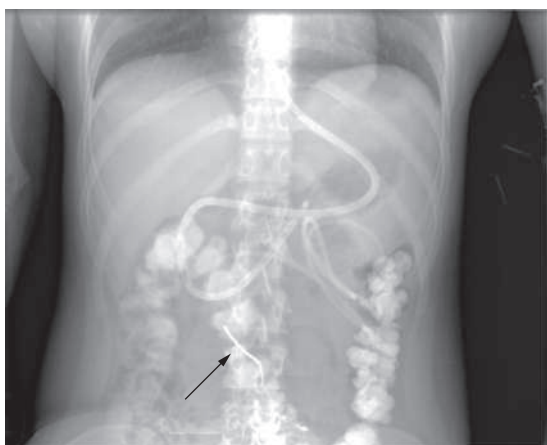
Radiographic image of the patient in Figure 3 that shows the final placement of a double-lumen feeding tube, which allowed simultaneous decompression of the stomach and distal jejunal feeding.
